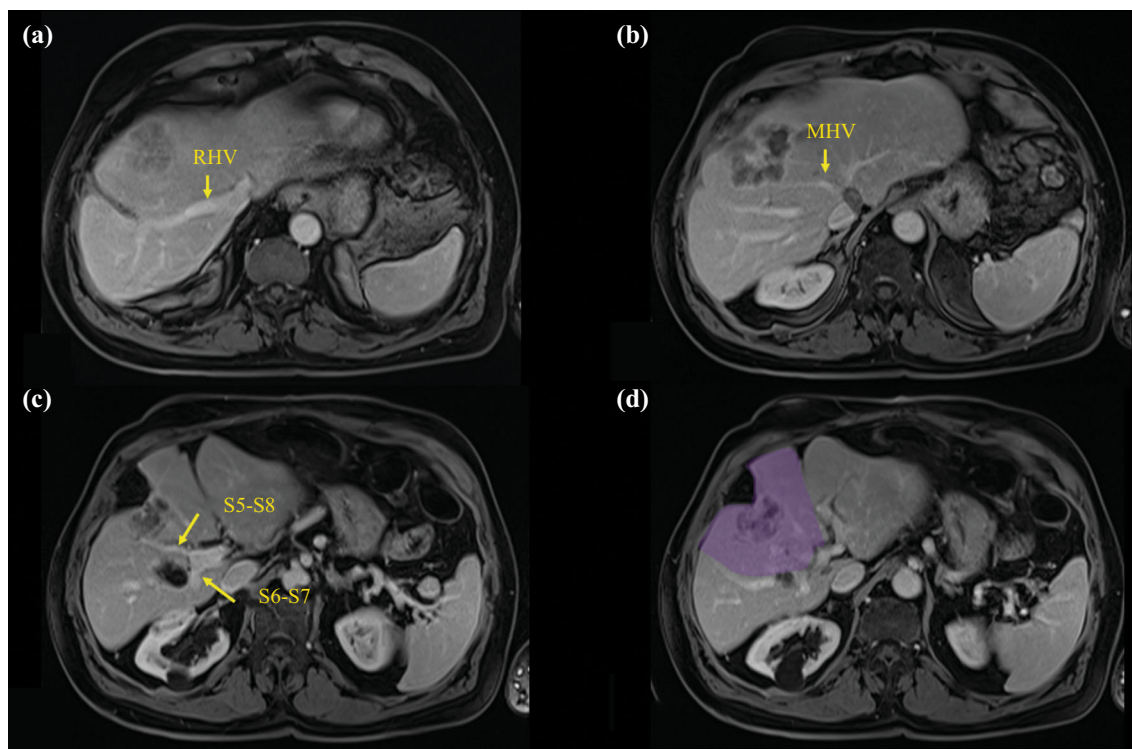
Preoperative MRI. A Axial view shows recurrent metastasis. RHV, right hepatic vein. B Axial view shows metastasis in close contact with the middle hepatic vein (MHV). C Axial view shows metastasis in close contact with the right anterior sector pedicle
